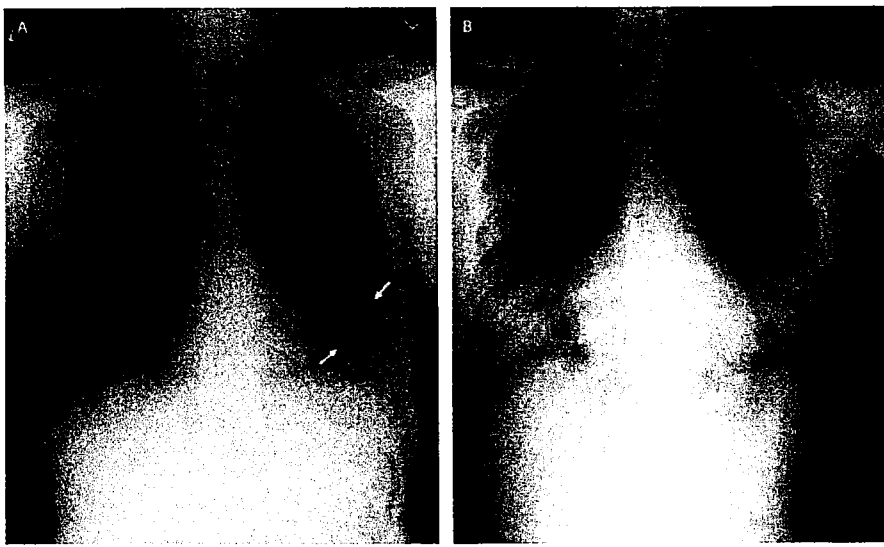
Chest x-rays of a 46-year-old man with SARS. The left lower lung infiltrate seen initially (A) progressed to multiple bilateral opacities (B). (Reprinted with permission from L Lee et al. © 2003 Massachusetts Medical Society.)
